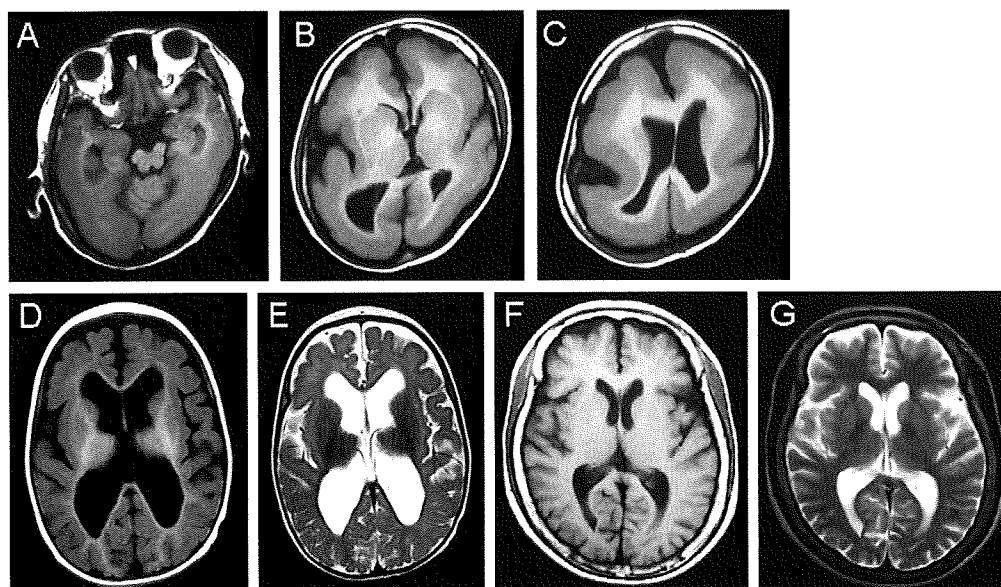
Brain MRI images of the three patients. (A–C) Grade 3 lissencephaly with predominant agyria in the posterior region was seen in patient 1. (D and E) Generalized hypoplasia of the brain involving the cortical and white matter regions was noted in patient 2. (F and G) Mild volume loss of the brain was identified in patient 3. (A–D, F) T1-weighted MRI image. (E and G) T2-weighted MRI image.
